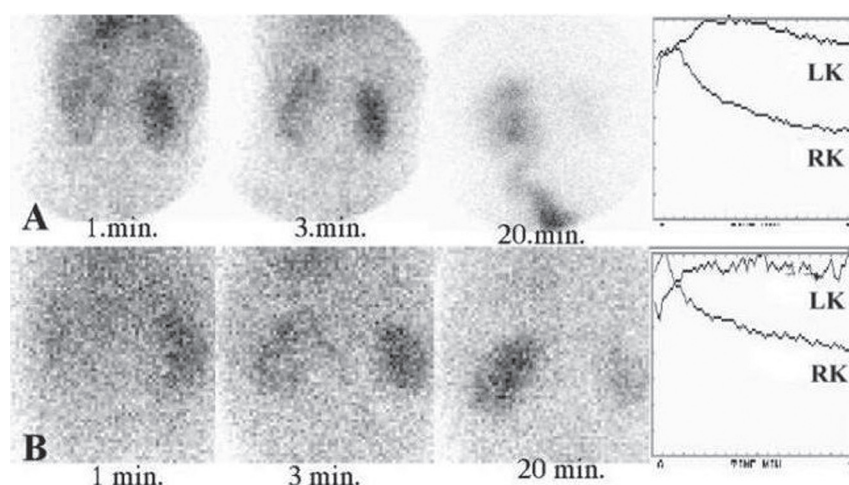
True positive diuresis renal scintigraphy "F-0" findings in children with left-sided obstruction of ureterovesical (A) and left-sided obstruction of ureteropyelic junction (B).
